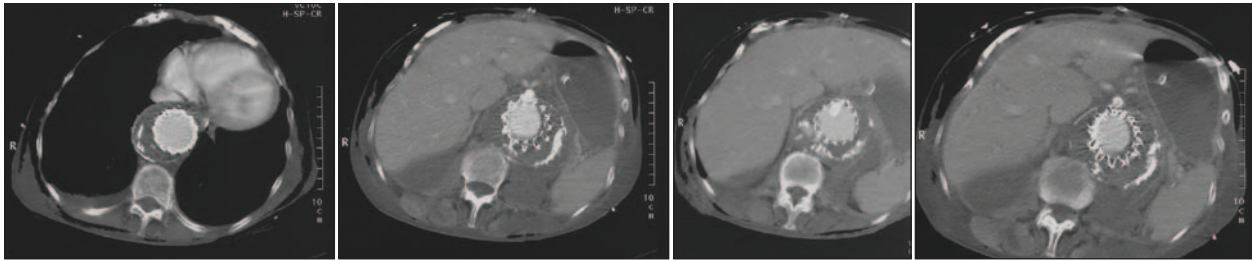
Computed tomography scan results at different levels 13 days after retrograde in situ fenestration and renal artery bypass showing patency of celiac trunk and SMA. The huge hematoma was asymptomatic.
